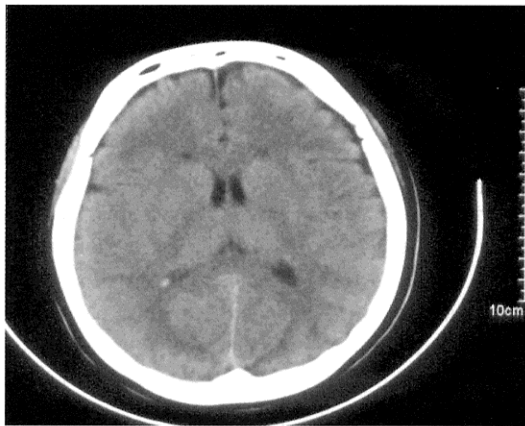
Cranial computed tomography on July 3, 2003, which revealed no diffuse brain edema.
